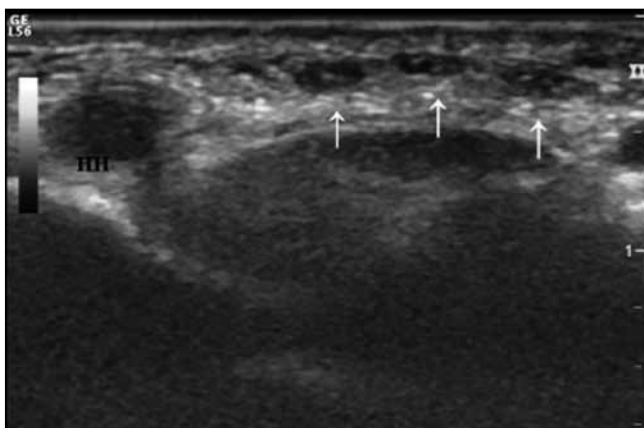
Axial ultrasound image of the median nerve in the left wrist; white arrows shows the three branches of the median nerve at the level of the hook of the hamate (HH) bone.
